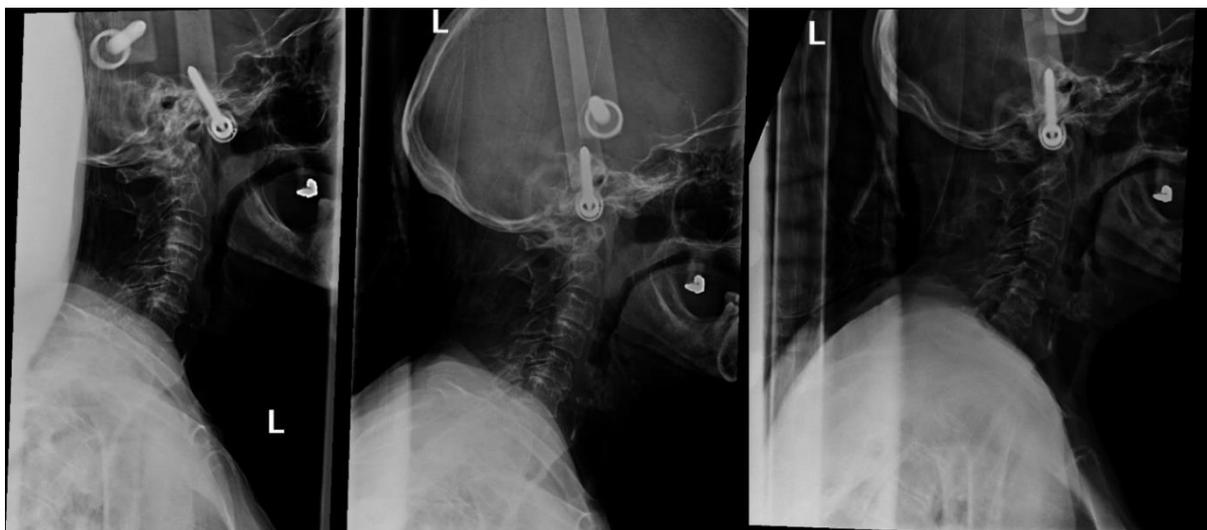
Post-operative plain film radiographs for Case 1 following C6-T1 ACDF and C4-T2 PCDF.
